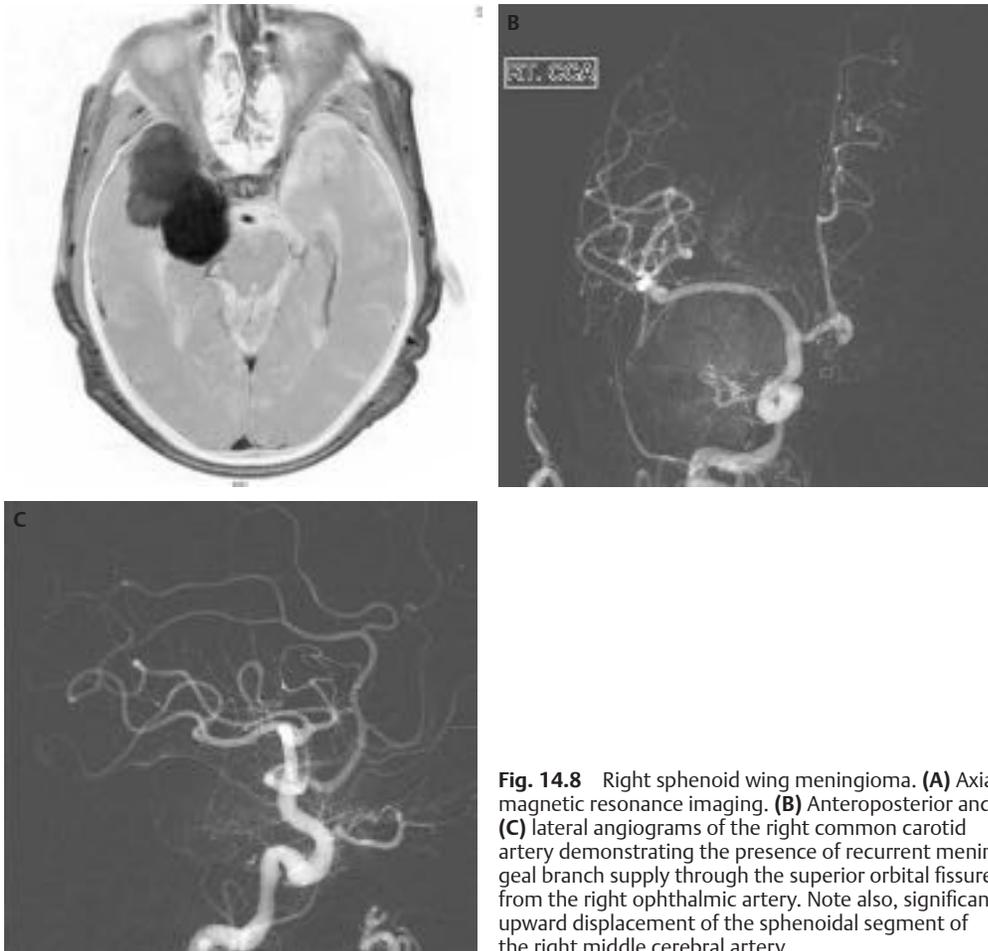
Right sphenoid wing meningioma. (A) Axial magnetic resonance imaging. (B) Anteroposterior and (C) lateral angiograms of the right common carotid artery demonstrating the presence of recurrent meningeal branch supply through the superior orbital fissure from the right ophthalmic artery. Note also, significant upward displacement of the sphenoidal segment of the right middle cerebral artery.
